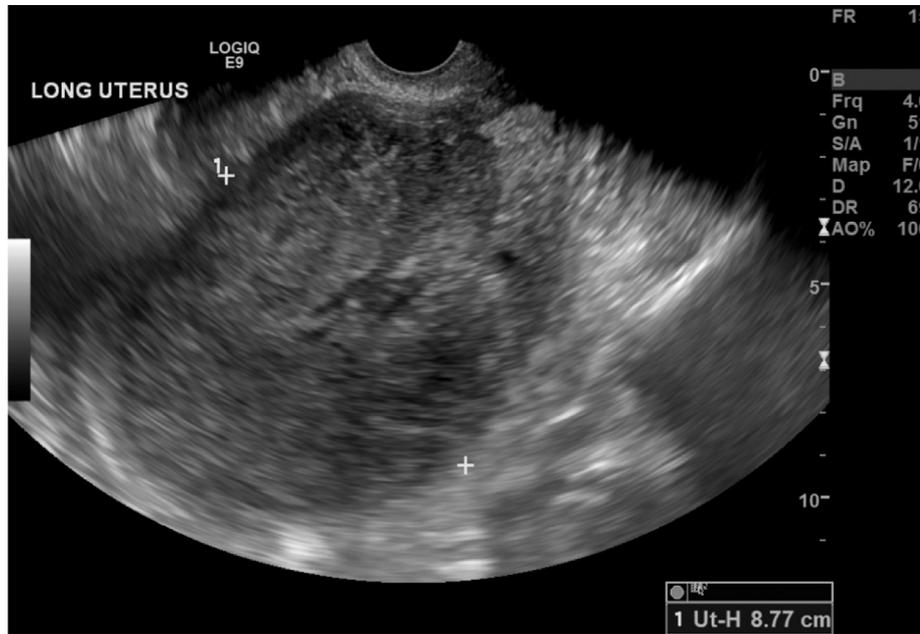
Sagittal ultrasound image shows UCS as heterogeneous mass distending the endometrial cavity. UCS, uterine carcinosarcoma.
